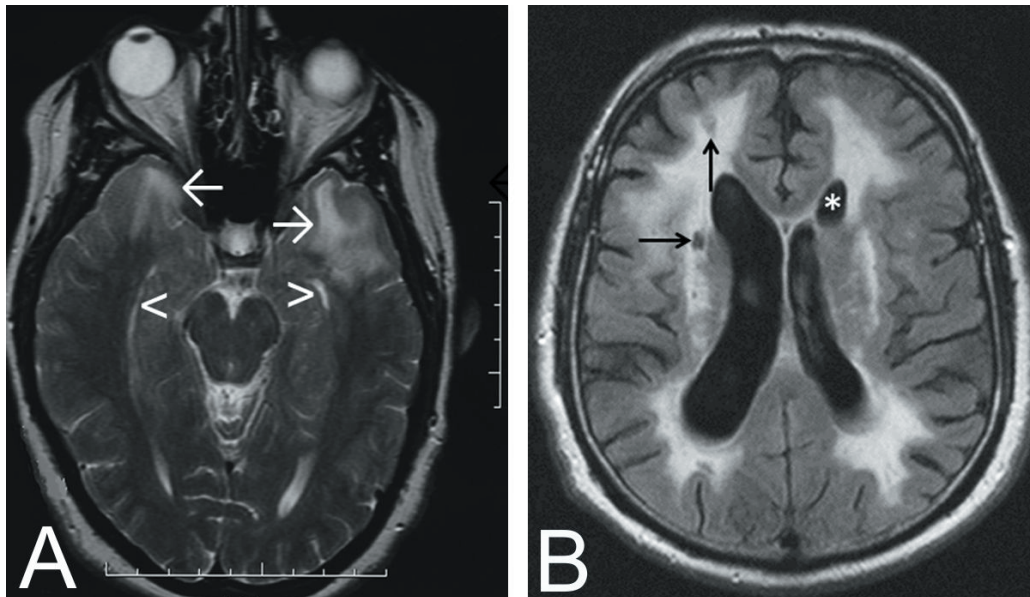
Typical findings in T2-weighted magnetic resonance imaging (MRI) in CADASIL patients. A) Characteristic MRI in the early stages of the disease (29-year-old female) shows hyperintensities in anterior temporal lobes (arrows) and in capsula externa (arrowheads). B) In the advanced stage of the disease, lacunar infarcts are visible both in the white matter and in basal ganglia (arrows) in fluid-attenuated inversion recovery MRI (57-year-old female). * = frontal horn of the lateral ventricle. Figures from the article by Kalimo et al. (2008), reproduced with the permission of the copyright holder.
